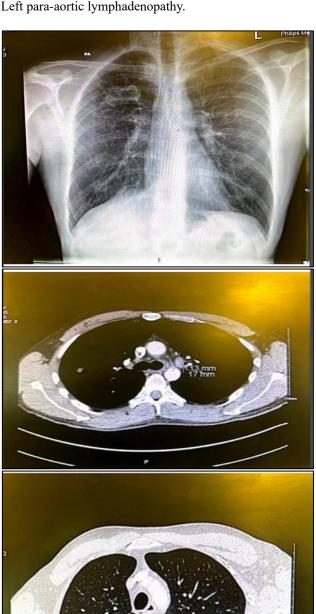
Radiological images for chest x-ray and CT scan.
